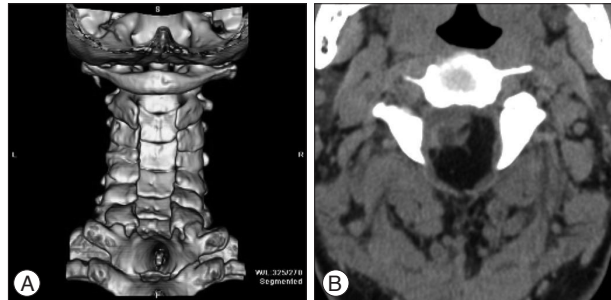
Preoperative CT image at the time of the first operation shows a hypodense tumor mass occupying the spinal canal almost entirely. Cervical spinal cord was severely compressed and located peripherally in the spinal canal.
